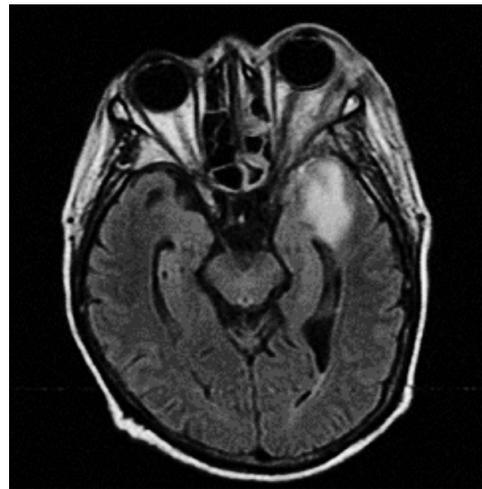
MRI of brain showed left periorbital cellulitis with small abscesses, intra – and extraconal fat involvement with extension to the left temporal lobe
